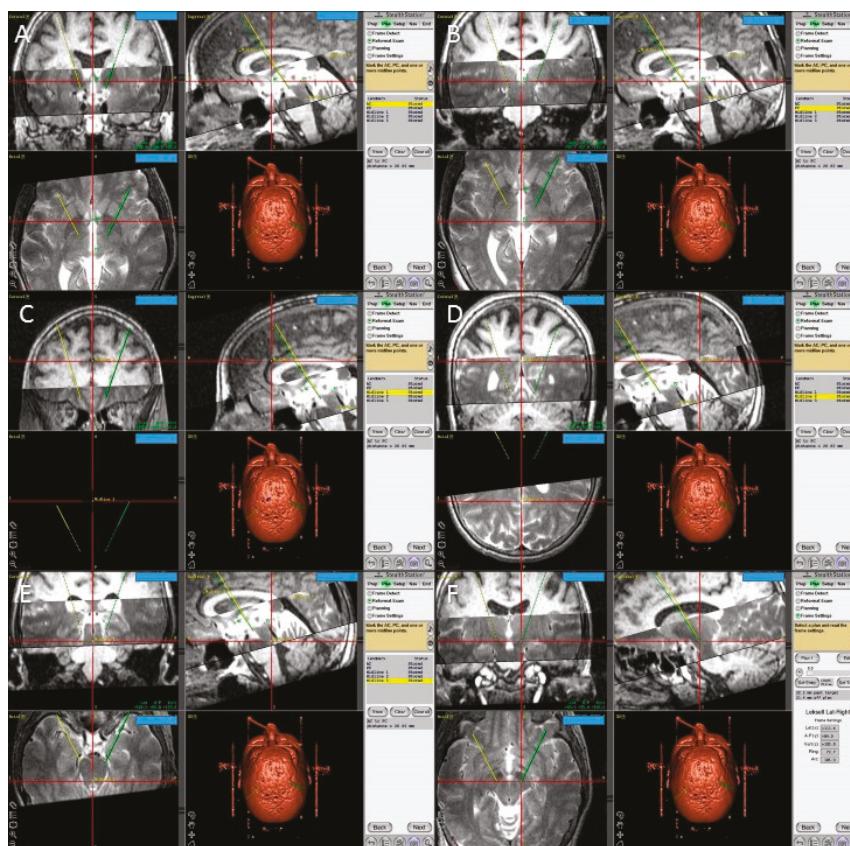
Screen shots from the Framalink software of the Stealthstation showing fused T1 and T2 MRI images of the patient and the planning process with identification of the posterior edge of the anterior commissure (AC) (A); the anterior edge of the posterior commissure (PC) (B); three midline points (C–E); and the final coordinates of the right subthalamic nucleus (F).
